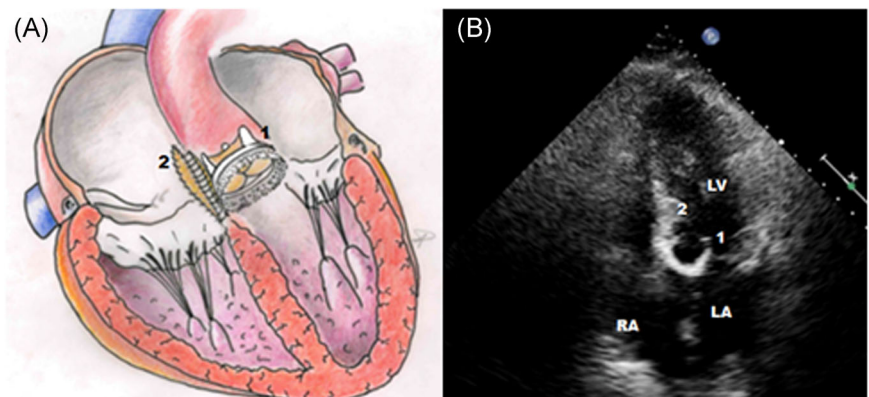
Postoperative result. A, 1: rapid-deployment aortic valve prosthesis; 2: double pericardial patch reconstruction. B, Echocardiographic control, 1: rapid-deployment prosthesis, 2: patch reconstruction. LA, left atrium; LV, left ventricle; RA, right atrium
